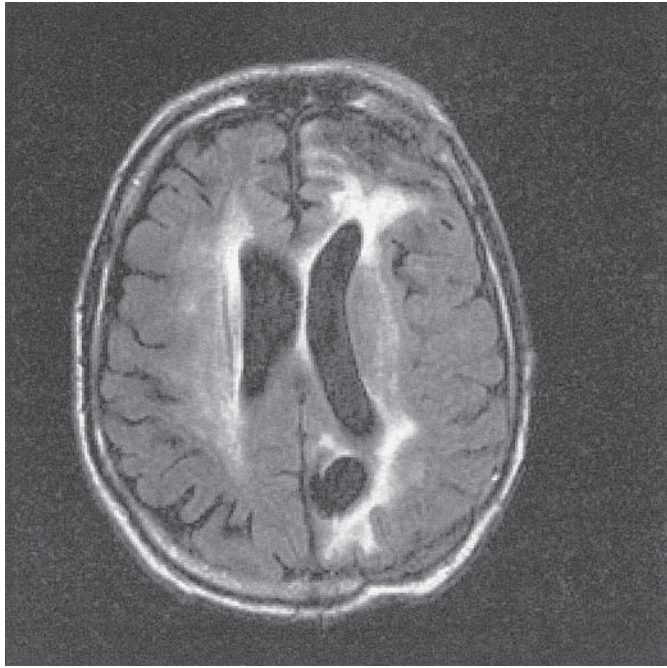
Toxicity WBRT. MRI scan, FLAIR image, 3 yr after WBRT and resection of a single metastatic melanoma lesion (left occipital). Patient is bedridden, has no sphincter control, and is demented from severe leucoencephalopathy.
